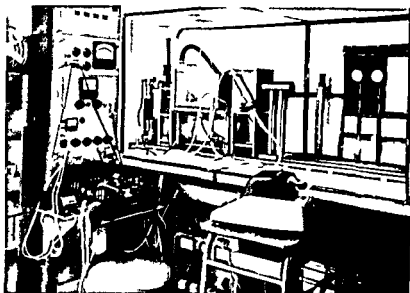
Vue d'ensemble de l'installation de mesure des rayons roentgen très mous.
